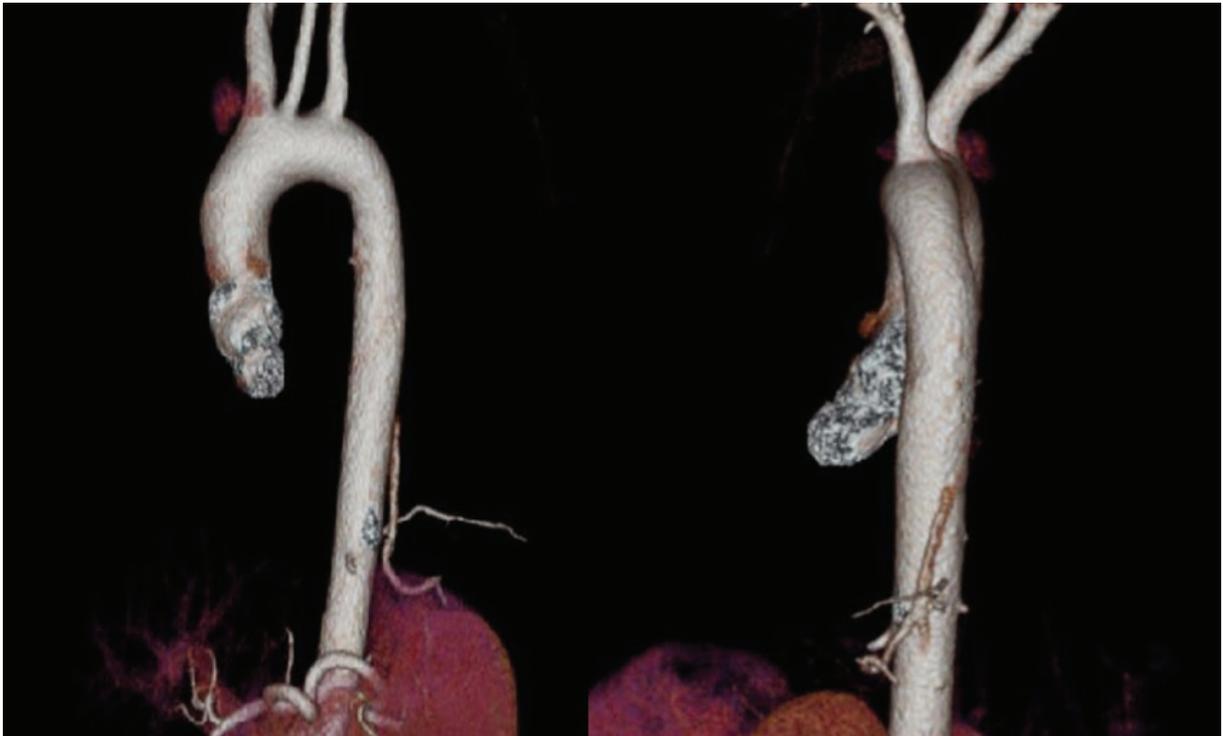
Contrast-enhanced thoracic computed tomography demonstrated two separate aberrant arteries originating from lower thoracic aorta.
